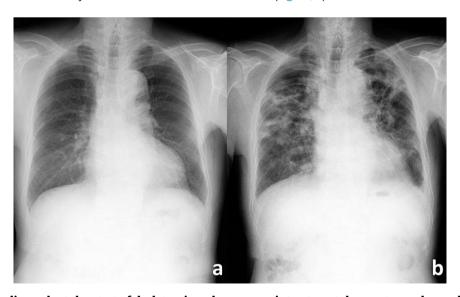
The chest radiograph at the start of daclatasvir and asunaprevir treatment does not reveal any abnormality (a). The chest radiograph on the first follow-up reveals bilateral opacities (b).
